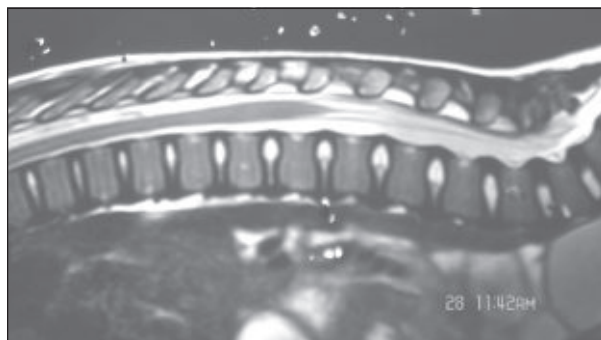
Normal MRI of spine of the first case
